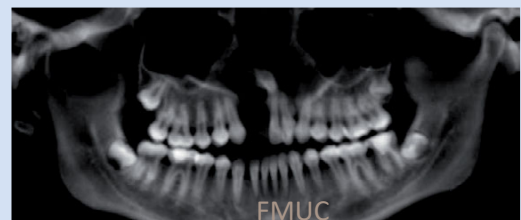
X-ray before distraction.
